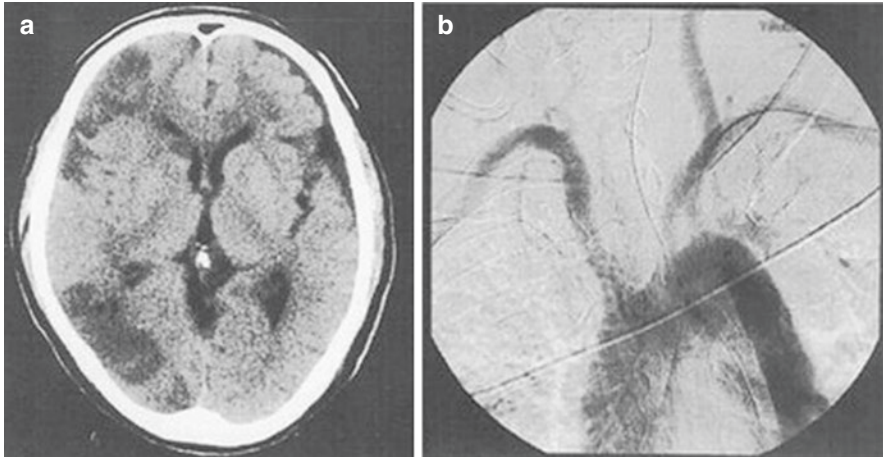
(a) Brain CT scan demonstrating multiple low-density infarctions in the right hemisphere, with moderate cerebral edema. (b) Arch angiogram of the same patient, demonstrating impaired flow through the right carotid artery as a result of the dissection process. It was thought that immediate surgical intervention was not appropriate in the acute phase of the dissection. Interval medical management was undertaken, with eventual aortic replacement 3 months after initial presentation (reproduced with permission [15])
